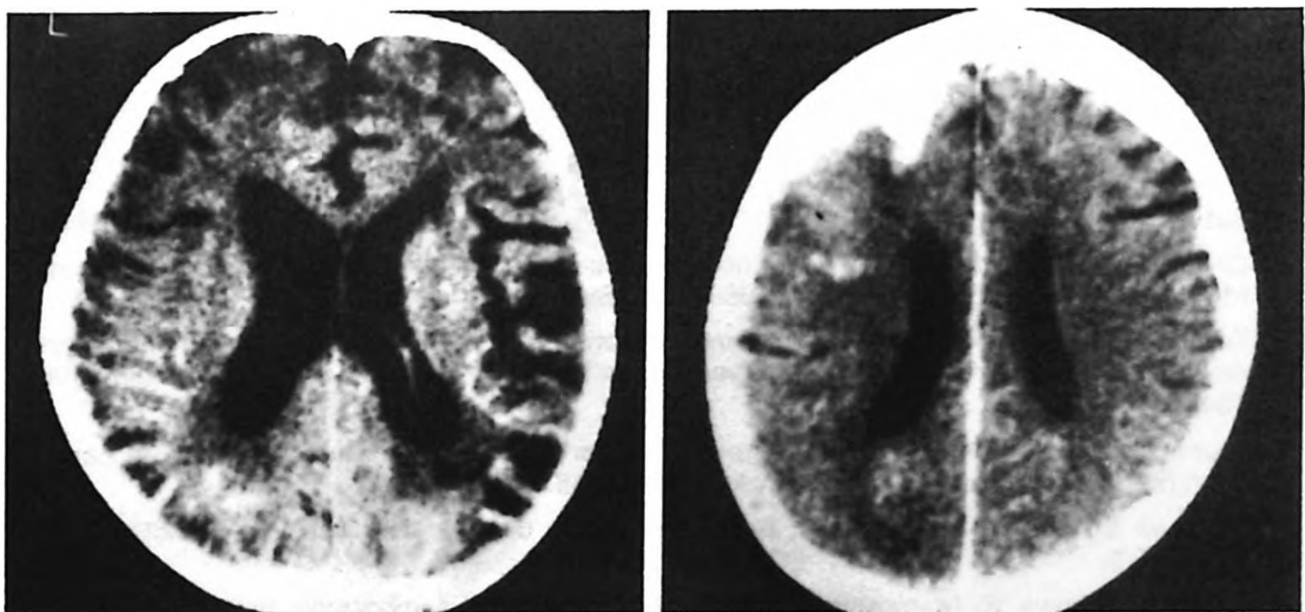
a) CT of Case 2: Cerebral atrophy and multiple cortical infarcts. b) CT of Case 3: Right frontal sub-acute cortical infarcts enhanced with contrast medium.
